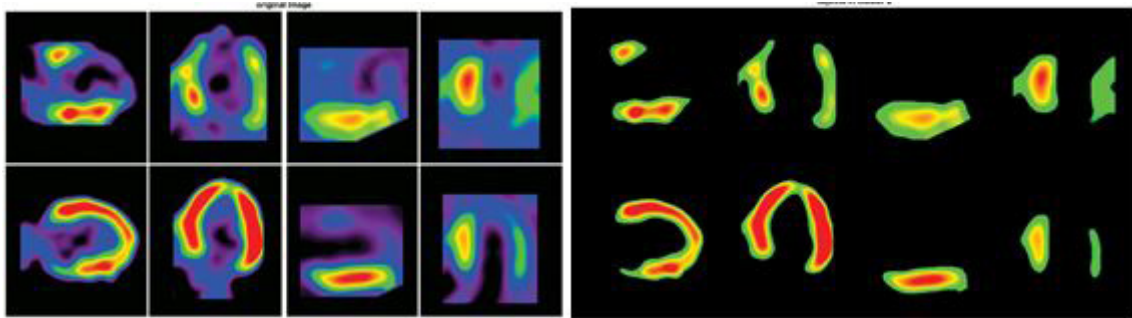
Segmented SPECT image obtained using k-means clustering techniques.
